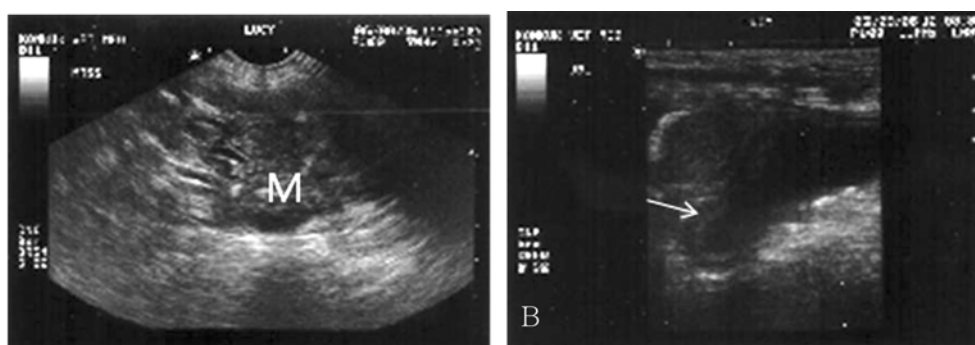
The mass was large, solid, slightly heterogeneous, and irregularly margined (A): Distortion of the urinary bladder vertex due to the mass (arrow) was identified by ultrasonography.
